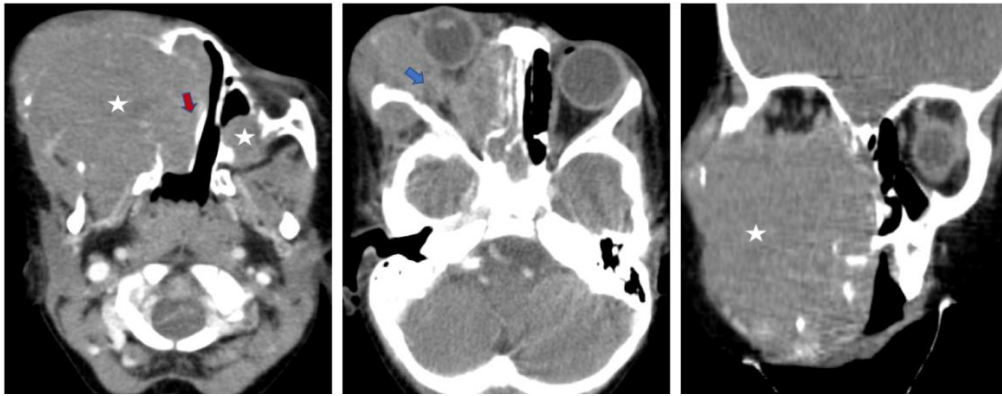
Facial CT scan showing two tumor processes centered on the maxillary sinuses (white star), the larger one being on the right and responsible for significant bone lysis with endo-orbital (red arrow) and endo-nasal (blue arrow) invasion but without endo-cranial extension
